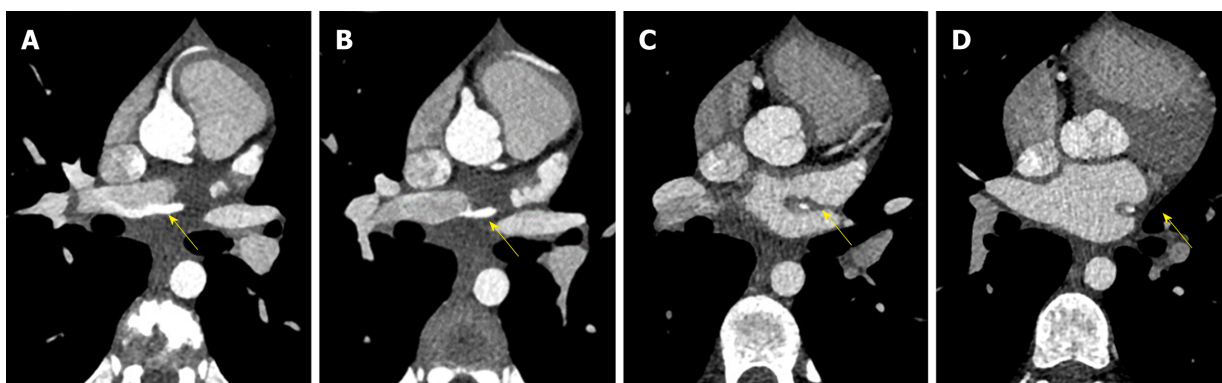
Course of circumflex artery. A-D: Course of circumflex artery between two left pulmonary veins shown with third generation dual source cardiac computed tomography (yellow arrow).
